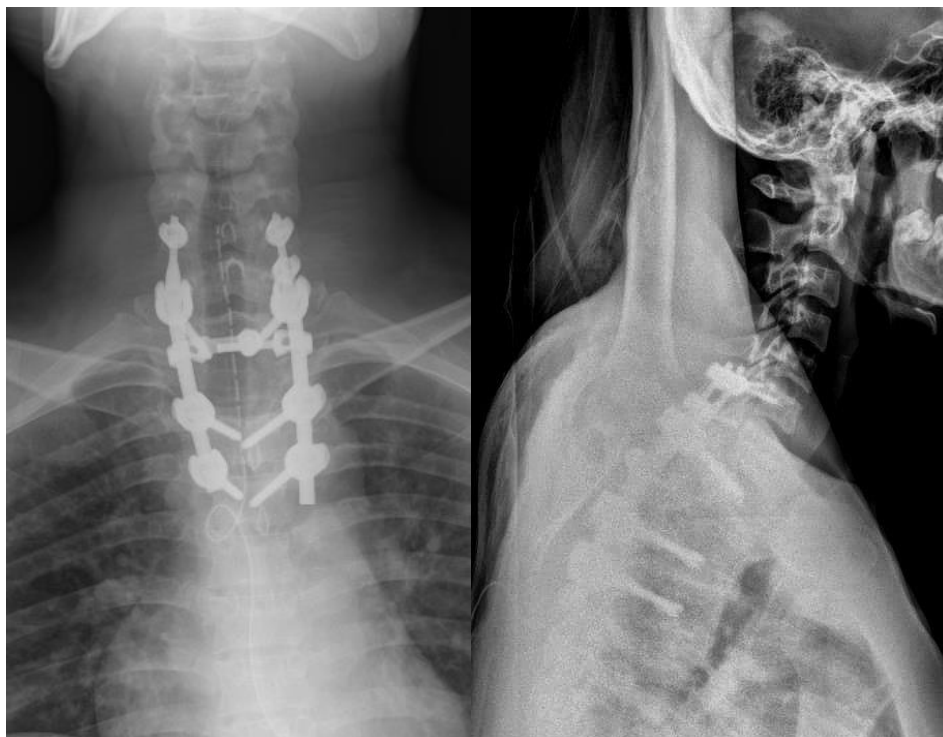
Postoperative X-Ray
